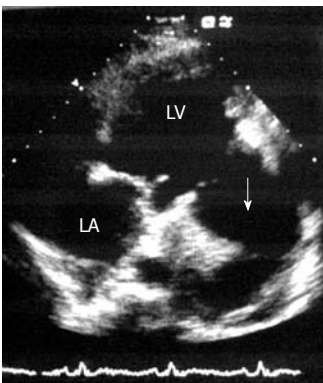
Echocardiography in apical 4-chamber view shows a large sub-mitral pseudoaneurysm (white arrow) containing a thrombus. LV: Left ventricular; LA: Left atrial.
